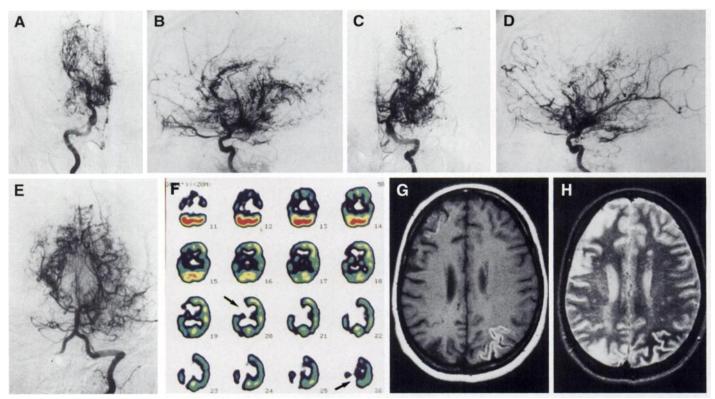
Images of an 18-yr-old woman with moyamoya disease. Right internal carotid arteriograms in frontal (A) and lateral (B) projections show that the right distal internal carotid artery and proximal anterior cerebral artery are stenotic and that the right middle cerebral artery is occluded. Marked MMVs are seen. Left internal carotid arteriograms in frontal (C) and lateral (D) projections show that the left distal internal carotid artery and proximal anterior cerebral artery are stenotic and that the left middle cerebral artery is occluded. Marked MMVs are seen. (E) Left vertebral arteriogram in a frontal projection shows that the right PCA is occluded and that the left PCA is markedly stenotic. Although MMVs are seen, there are no leptomeningeal collateral vessels to the anterior circulation. (F) Axial SPECT images show extensive areas of decreased rCBF in bilateral cerebral hemispheres. Particularly, large perfusion defect areas (arrows) are noted in the right frontal and parietal lobes. (G) Axial T1-weighted MR image (600/20) shows extensive infarctions in the right frontal and bilateral parietal lobes. (H) Axial T2-weighted MR image (3,000/80) shows extensive infarctions in the right frontal and bilateral parietal lobes.
